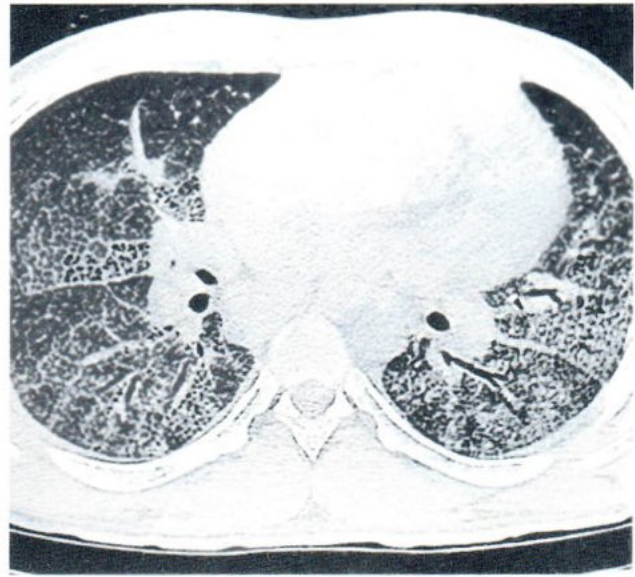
Endogenous lipid pneumonia. HRCT chest of a 23-year-old man, who presented with productive cough and progressive dyspnea for 2 mo., revealed diffuse crazy-paving pattern in both lungs fields. The pathologic findings highly suggested to be lipid pneumonia.
